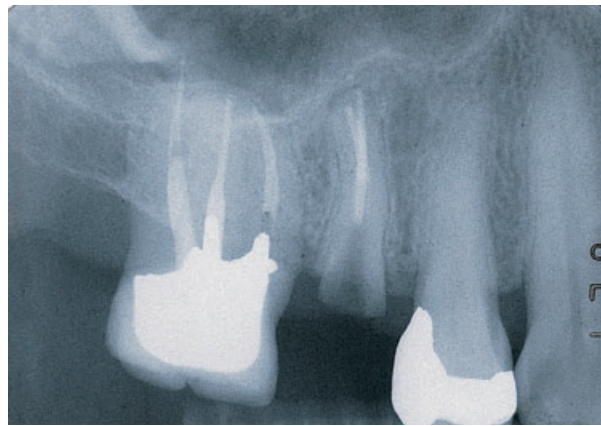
Ad hoc radiograph of the upper right posterior sextant. One notes the presence of a structurally compromised second premolar. The treatment of that particular root would require build-up and crown lengthening (margin exposure, creation of an adequate ferrule) which in turn would negatively affect the adjacent teeth.
